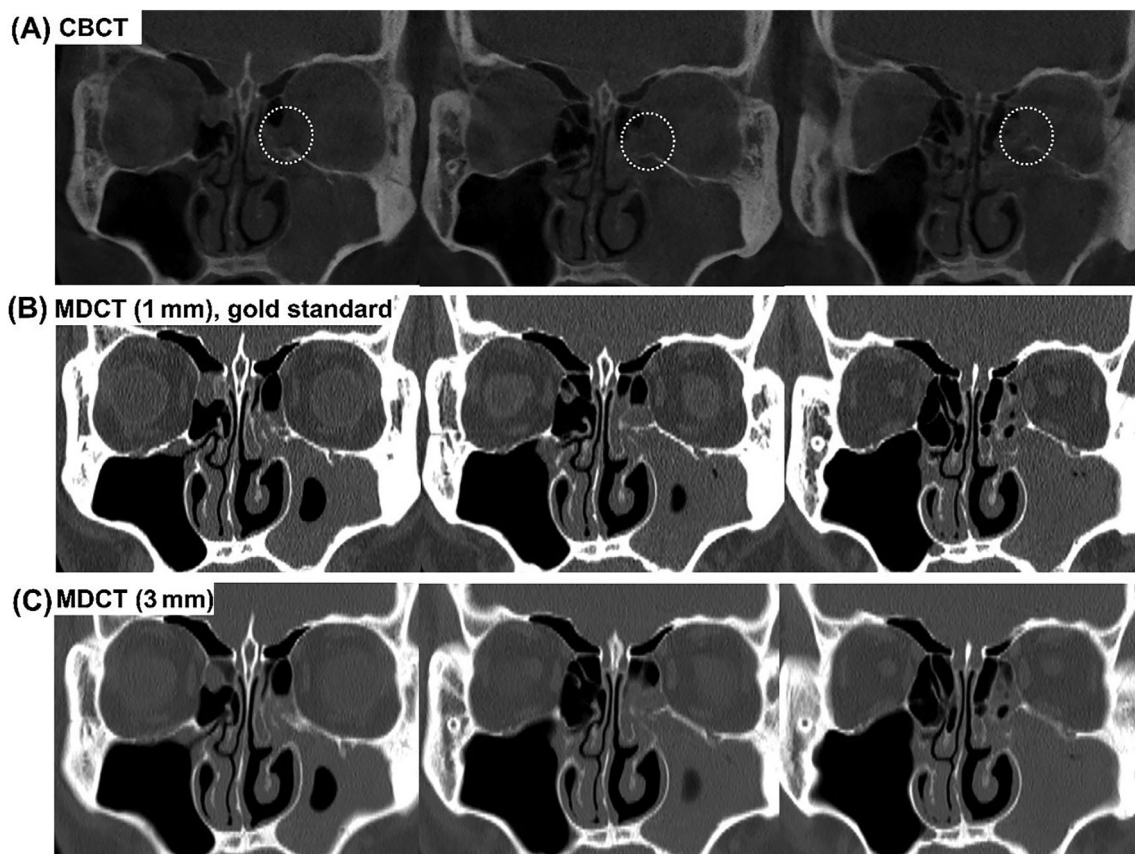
Lamina papyracea dehiscence (inside the dashed circle) is suspected on (A) CBCT with 0.3 mm thickness. However, an intact lamina papyracea is identified on MDCT with (B) 1 mm thickness and (C) 3 mm thickness. CBCT, cone-beam computed tomography; MDCT, multi-detector computed tomography
